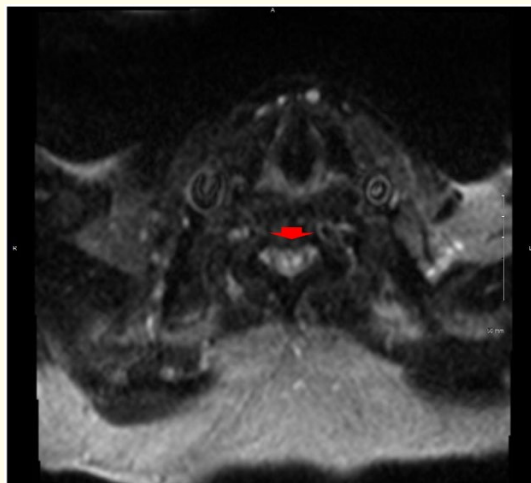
Diffusion weighted imaging (DWI) sequence in axial section at cervical vertebra C6 level demonstrating hyperintensity in the spinal cord concerning cytotoxic injury from ischemia (Arrow).
